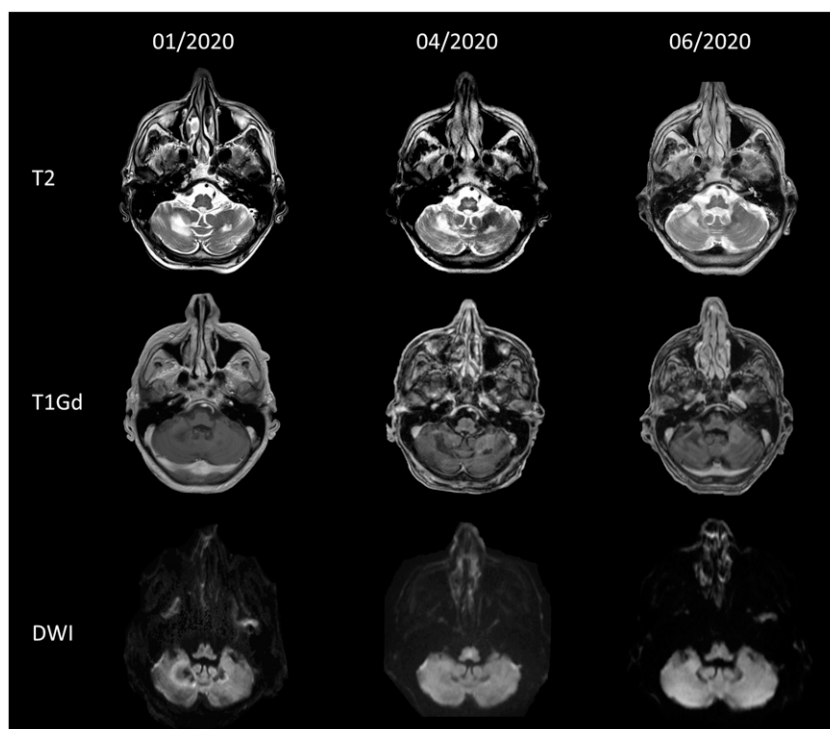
Magnetic resonance imaging findings over time. Upper row: T2-weighted axial images show hyperintense white-matter lesions in the cerebellum. Middle row: Axial T1 gadolinium (Gd)-weighted images show no Gd-enhancement. Lower row: Axial diffusion weighted image shows no restricted diffusion.
